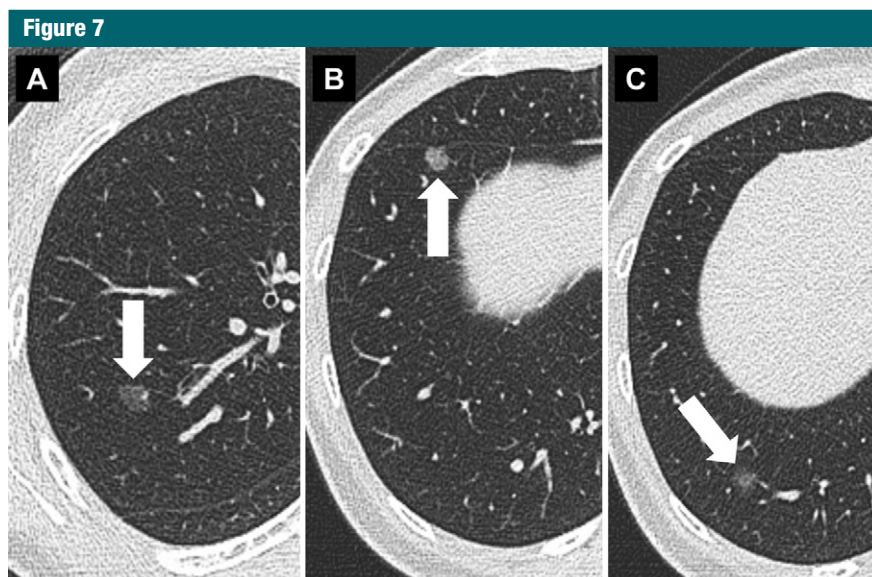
Multiple GGNs larger than 5 mm in the absence of a dominant lesion. CT scans obtained with 1-mm-thick sections through right upper lobe (A) and lower lobes (B, C) show three separate GGNs larger than 5 mm (arrows), all of approximately the same size. In the absence of a dominant lesion, conservative management with an initial follow-up examination in 3 months followed by yearly CT examinations was recommended.
